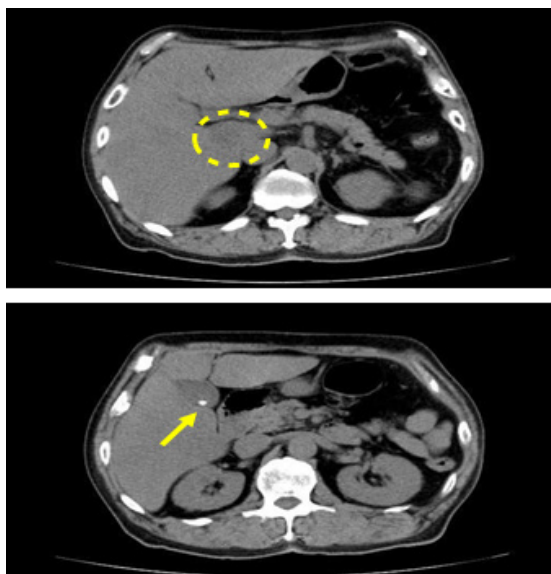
Findings of abdominal CT.
